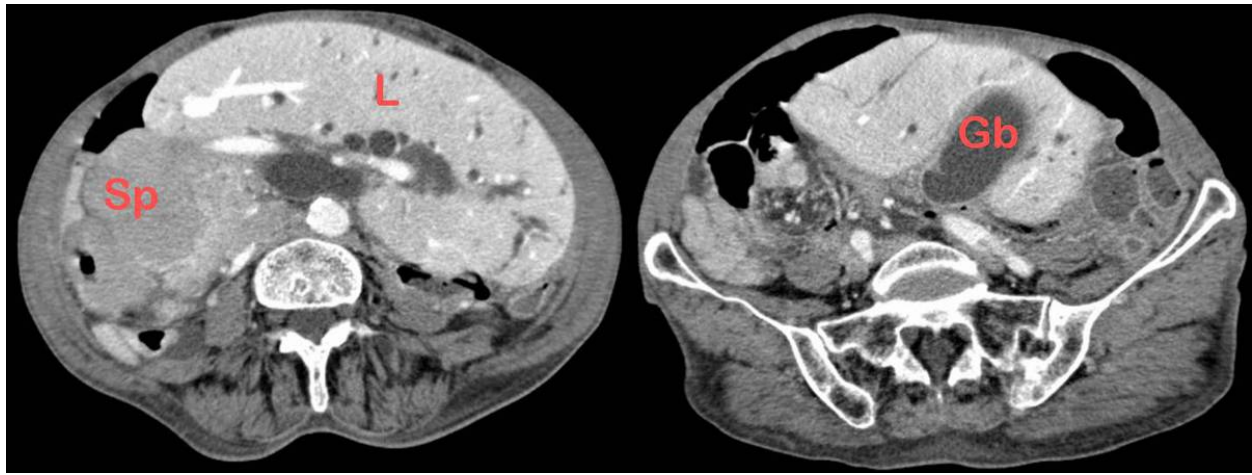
Transverse contrast-enhanced CT scan of the abdomen shows a midline liver and multiple spleens (Sp) in the right upper quadrant. The low attenuation of the spleens is related to infarctions. Note the absence of splenic tissue in the left upper quadrant. Transverse CT scan through the midabdomen reveals a midline gallbladder (Gb).
